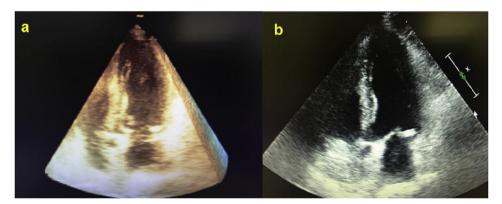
3D (Figure a) and 2D (Figure b) Transthoracic echocardiography showed that there was no metastatic mass and contractility deficit in the right and left ventricle.
